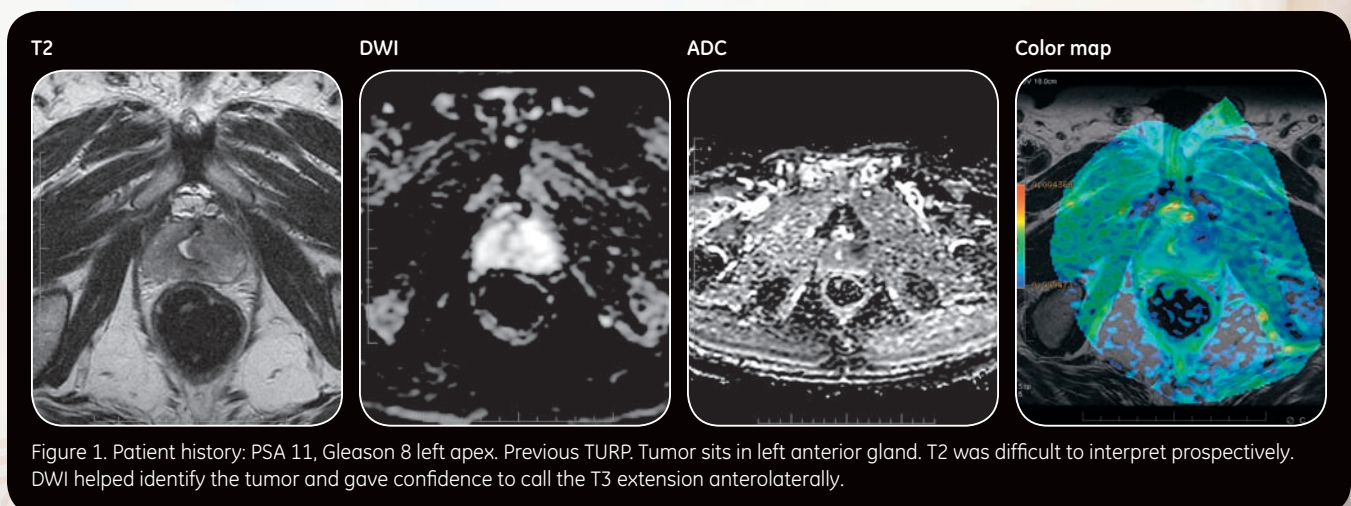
Patient history: PSA 11, Gleason 8 left apex. Previous TURP. Tumor sits in left anterior gland. T2 was difficult to interpret prospectively. DWI helped identify the tumor and gave confidence to call the T3 extension anterolaterally.
